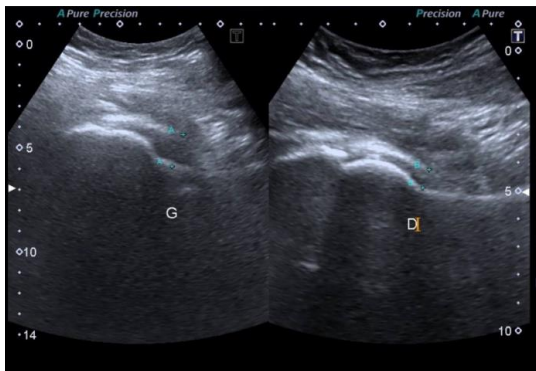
Intra-articular collection of images of the left hip joint (by ultrasound and X-ray)
